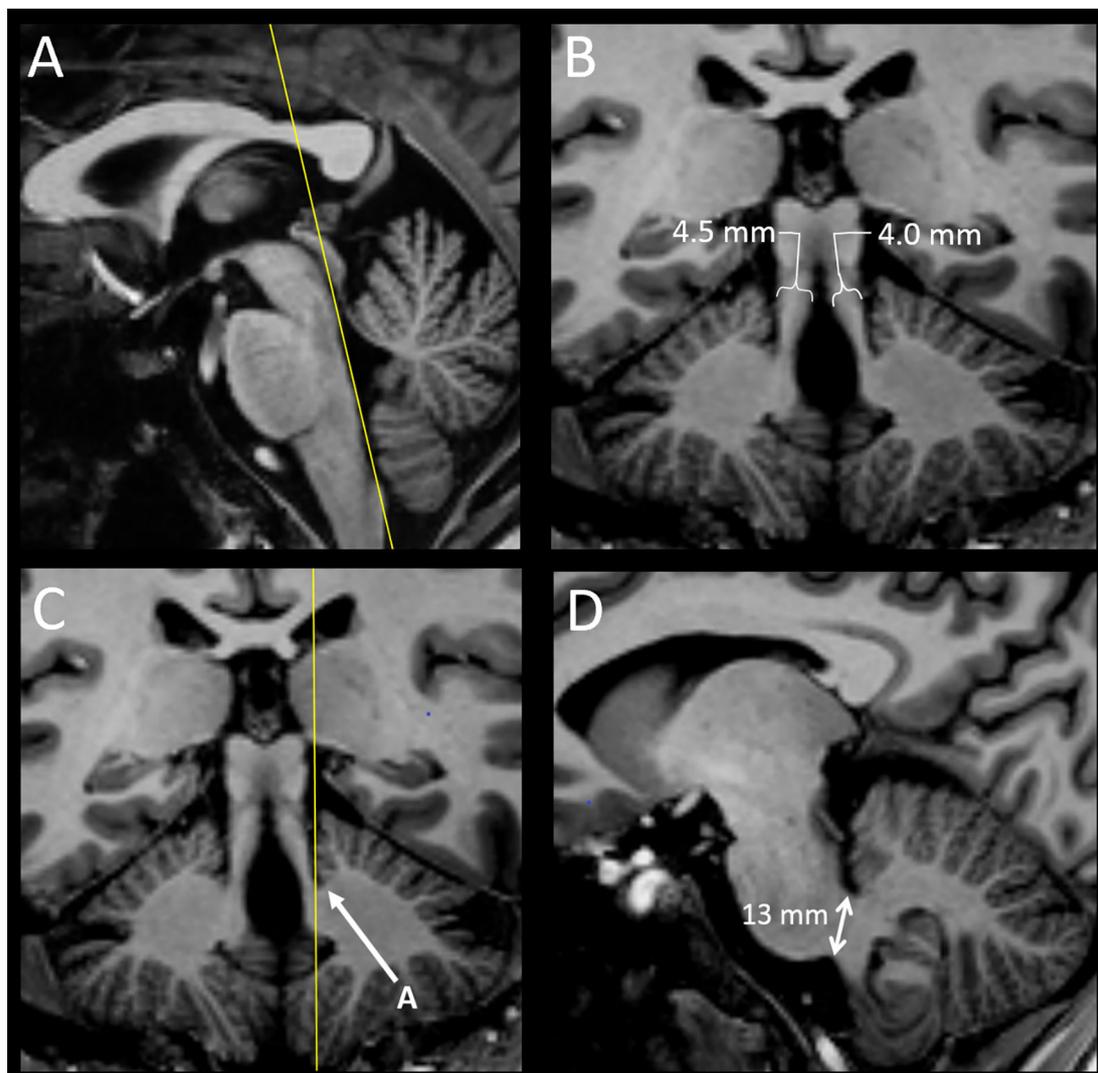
Measurement of the width of the SCP (A,B) and MCP (C,D). *A:* Midsagittal plane from a T1-weighted MPRAGE sequence. The yellow line is parallel to the posterior margin of the midbrain-pontine-medullary contour. *B:* Coronal oblique plane that is parallel to the yellow line in the left image. The width of the SCP is shown by the white bracket, obtained at the 50% point between the pons and midbrain. In this example, the width is 4.5 mm on the right and 4.0 mm on the left. *C:* The yellow line is parallel to the midline and passes through the notch between the peduncle and the cerebellar folia (A). *D:* Sagittal plane parallel to the yellow line in the left image. The width of the MCP is shown by the double-headed arrow and measures 13 mm in this example. (Images obtained at 7 T using an MP2RAGE sequence.)
